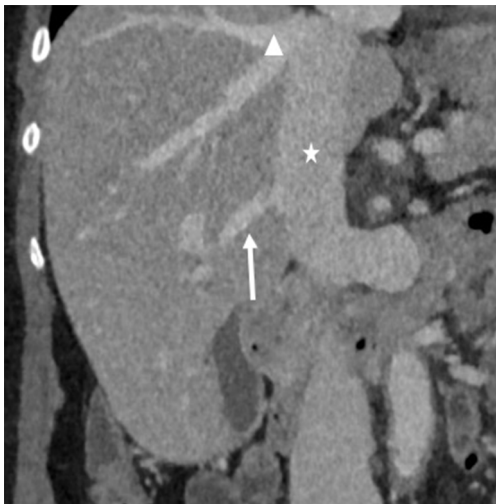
Coronal image of a portal venous phase CT demonstrating an accessory/inferior right hepatic vein (arrow) from segment VI draining into the inferior vena cava (*) inferior to the main right hepatic vein (triangle).
